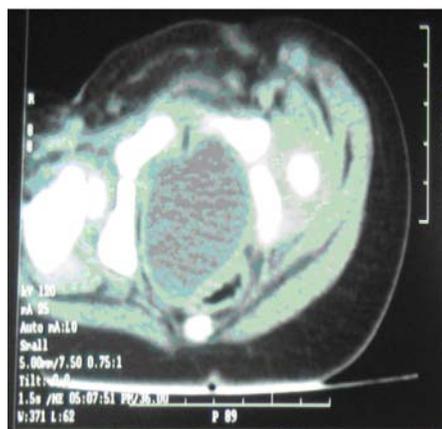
CT scan showed retroperitoneal swelling filled with fluid in the uterus between rectum and urinary bladder.
